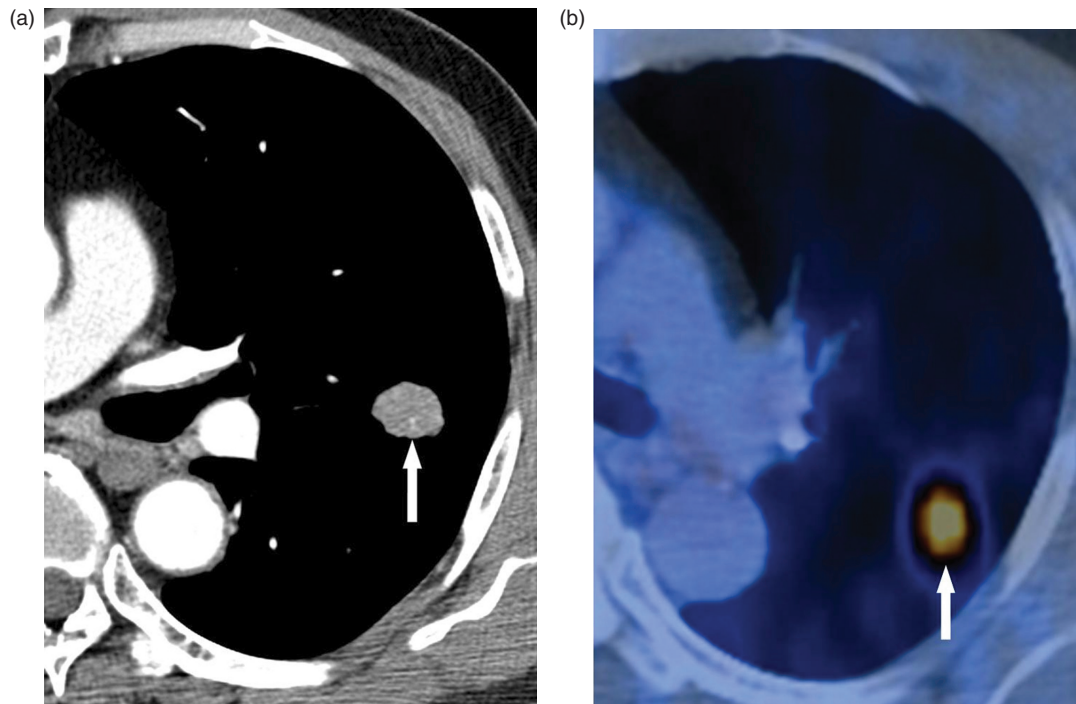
A 70-year-old man with a large cell neuroendocrine cell carcinoma (T1N0M0, IA). (a) Mediastinal window image of a transverse contrast-enhanced CT scan (5-mm section thickness, 130 mAs) obtained at the level of the left upper divisional bronchus shows a 19-mm-sized peripheral nodule (arrow) in the left lower lobe. (b) Integrated PET/CT scan shows high FDG uptake (arrow) within the tumor (SUV_{max} , 10.7).
